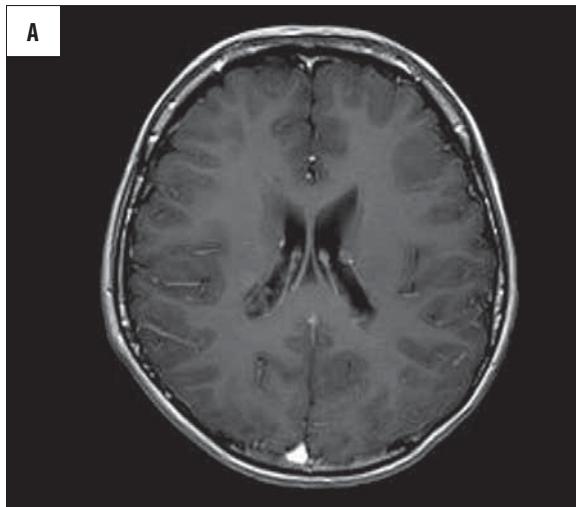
MR tomography of the head; T1-weighted, contrast-enhanced images – a few contrast-enhanced tumors up to 9 mm in diameter (hamartoma) visualized in the walls of both lateral ventricles.
